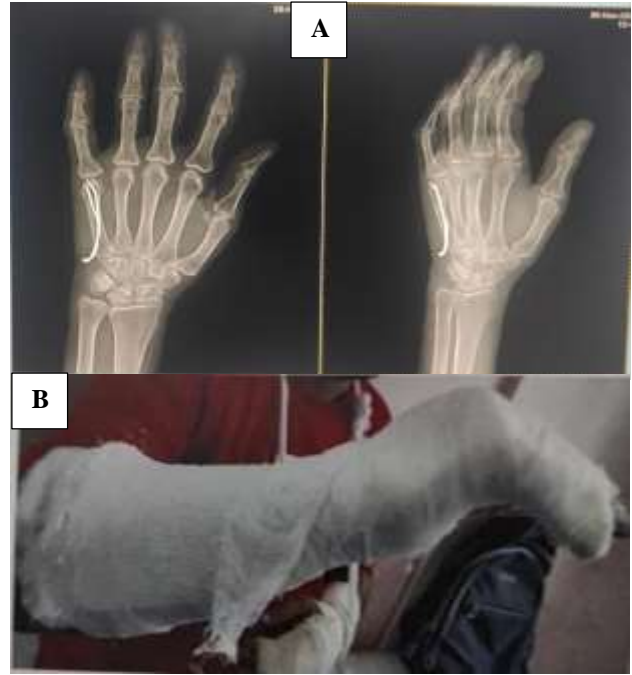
Post-op x-ray and cockup slab. 4A) Post-op x-ray, 4B) Post operatively cockup slab is applied.
